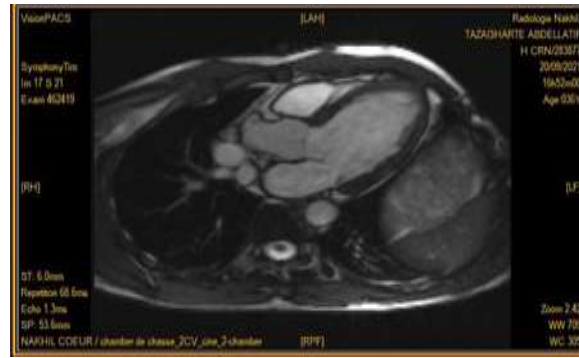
3 chamber view on Cardiac MRI.
